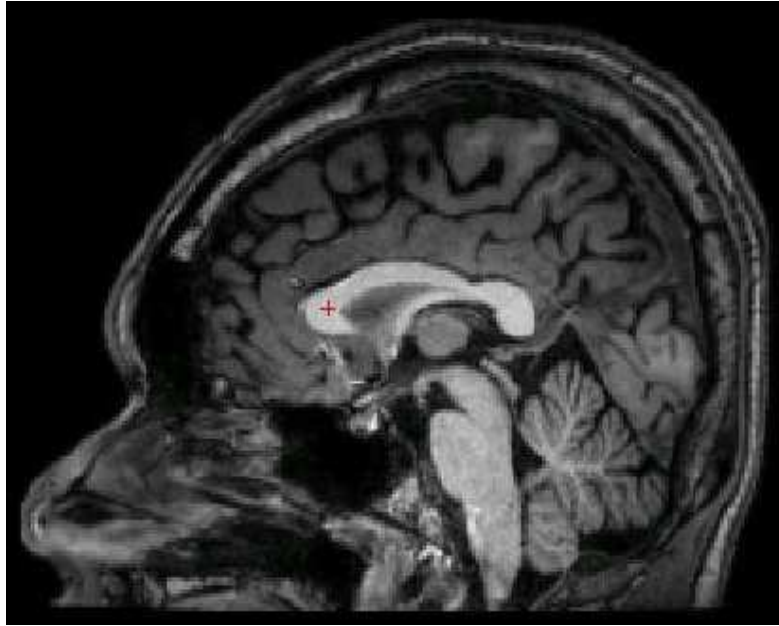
MRI of the human corpus callosum. The CC is indicated with a red cross.
